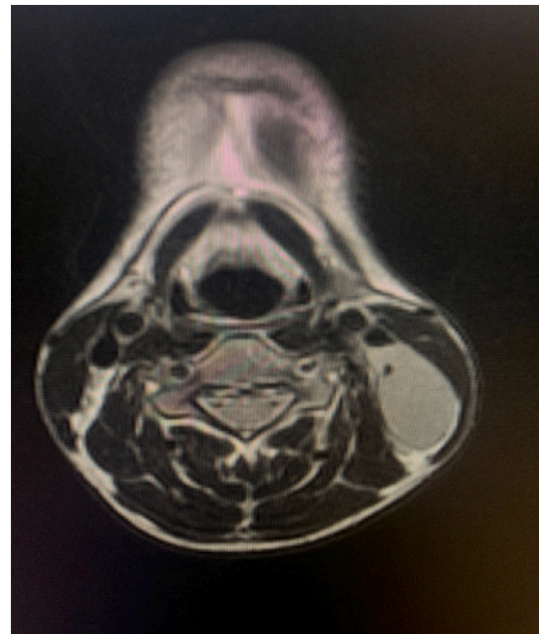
T2 MRI demonstrates a hyper-intense mass with flow void.
